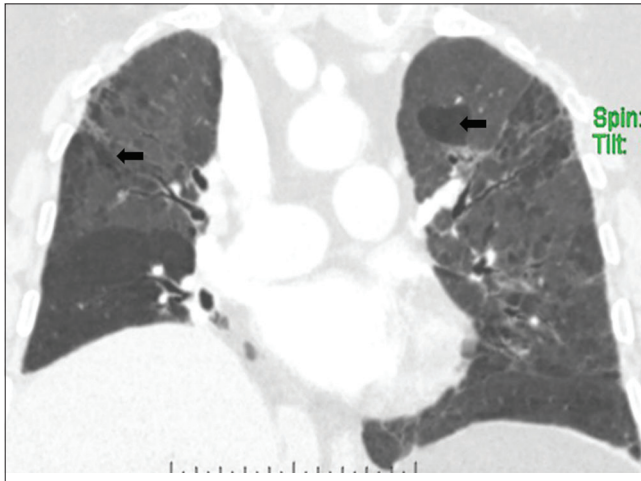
Minimum-intensity projection images of high-resolution computed tomography lungs in coronal plane showing extensive areas of hypoattenuation (arrows) in this patient with airway disease. The areas of hypoattenuation signify air trapping
